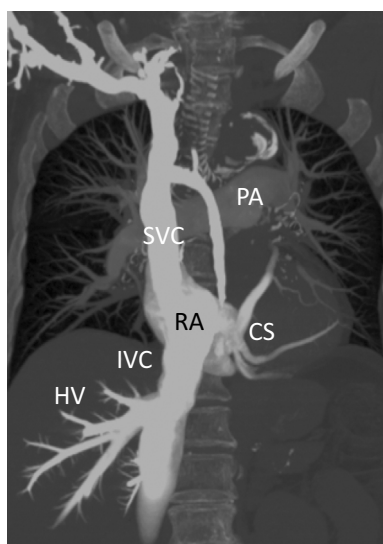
Maximum intensity projection (MIP) image of multi-detector row computed tomography shows excessive contrast in the systemic venous system, including the superior vena cava, inferior vena cava, hepatic vein, and coronary sinus, but faint contrast in the pulmonary circulation and no pulmonary embolism. These findings indicate severe right ventricular dysfunction; the majority of the contrast did not flow into the pulmonary circulation, but instead spilled over into the systemic venous system. CS: coronary sinus, HV: hepatic vein, IVC: inferior vena cava, PA: pulmonary artery, RA: right atrium, RV: right ventricle, SVC: superior vena cava
